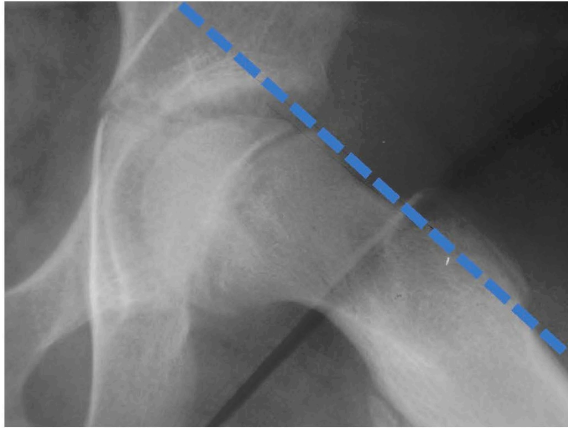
Frog leg lateral radiograph of paediatric left hip. Klein's line drawn along superior aspect of femoral neck – A slipped upper femoral epiphysis is evident as the line does not intersect the femoral head. (Annotated original image from, Wikipedia, 2019)
